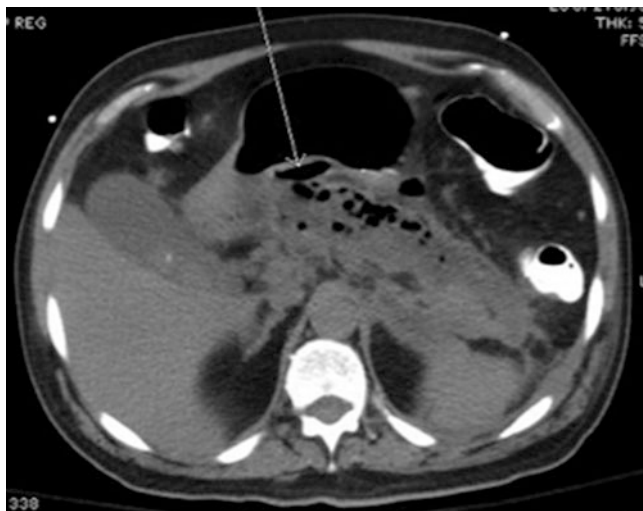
CT scan with air bubbles in pancreatic fluid collection demonstrates signs of infected necrotizing pancreatitis
